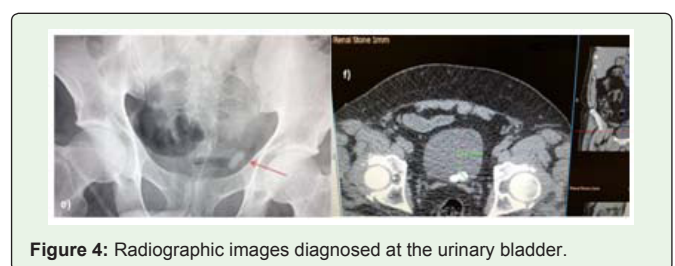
Radiographic images diagnosed at the urinary bladder.
